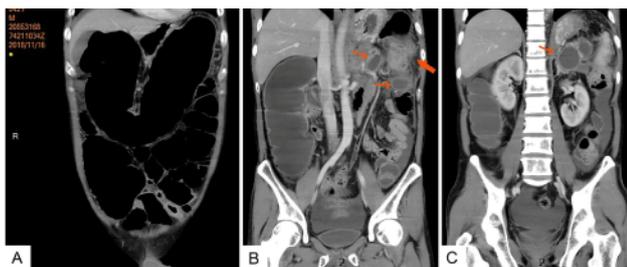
Pre-operative abdominal CT. A: Proximal colon with severe distension; B: Obstructing descending colon mass (broad arrow); B and C: Several pancreatic pseudocysts (thin arrows) causing mass effect displacing left kidney inferiorly.
